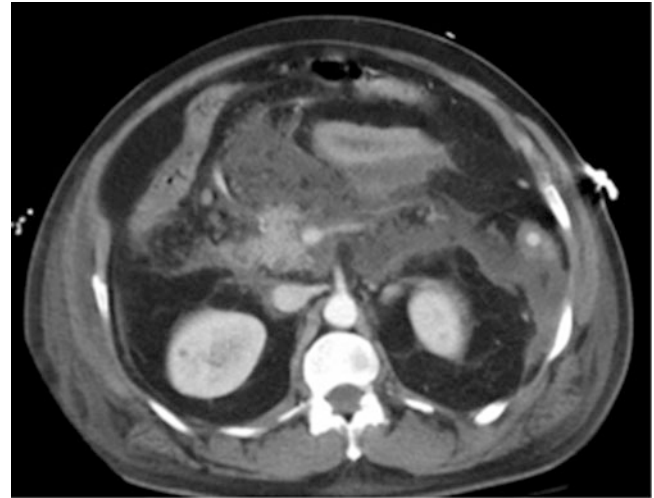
CT scan with significant retroperitoneal fluid tracking along left colic gutter
